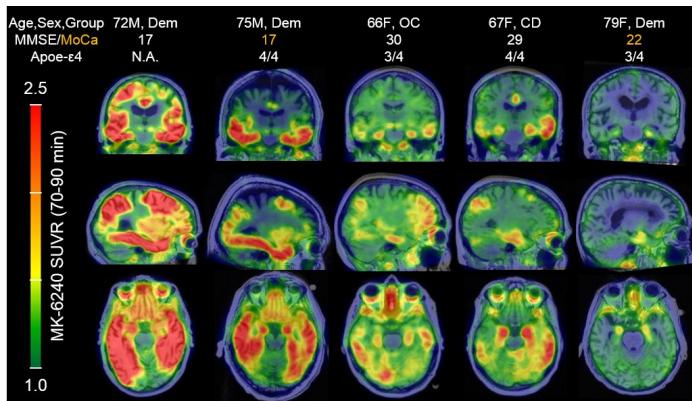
$[^{18}\text{F}]$ MK-6240 parametric SUVR (70-90 min) images in PiB(+) individuals organized by image-based Braak stages. $[^{18}\text{F}]$ MK-6240 spatial binding patterns in PiB(+) individuals recapitulated patterns consistent with neuropathological staging of Alzheimer's disease, including in the hippocampus. The PiB(+) dementia case in the far rightward column was clinical diagnosed with probable AD dementia (not informed by these biomarkers) but exhibited only circumscribed $[^{18}\text{F}]$ MK-6240 signal in the entorhinal region.
